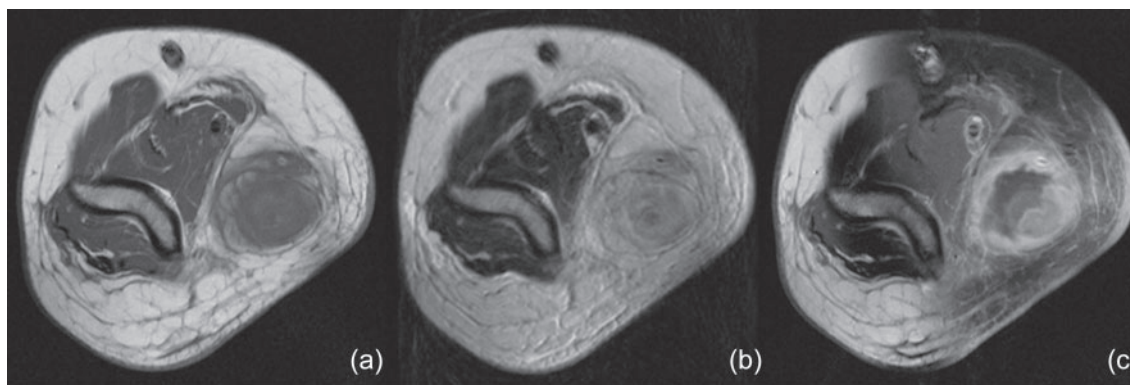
Magnetic resonance imaging showing a subcutaneous soft tissue mass (27×22×26 mm in size) on the medial side of the patient's elbow. The mass demonstrates iso-signal intensity on the T1-weighted image (a), inhomogeneous high-signal intensity on the T2-weighted image (b), and ring enhancement on the gadolinium-enhanced T1-weighted image (c).
